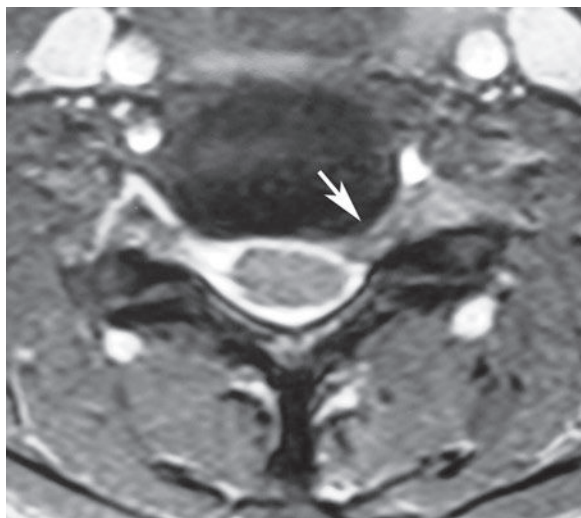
An axial T2-weighted image at the C5-C6 level shows a lateral or foraminal disc protrusion (*arrow*) on the left side, which produces severe foraminal stenosis and compresses the nerve root. Note that the signal is different from that of the bone.[†]
